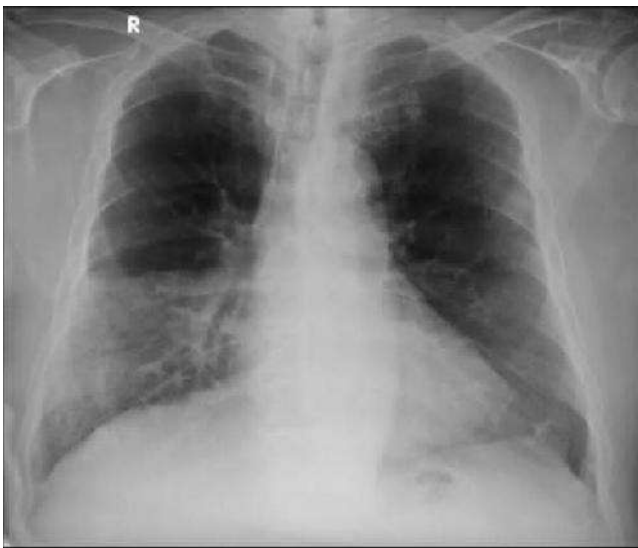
Chest X-Ray when he first admitted for being positive for COVID-19
